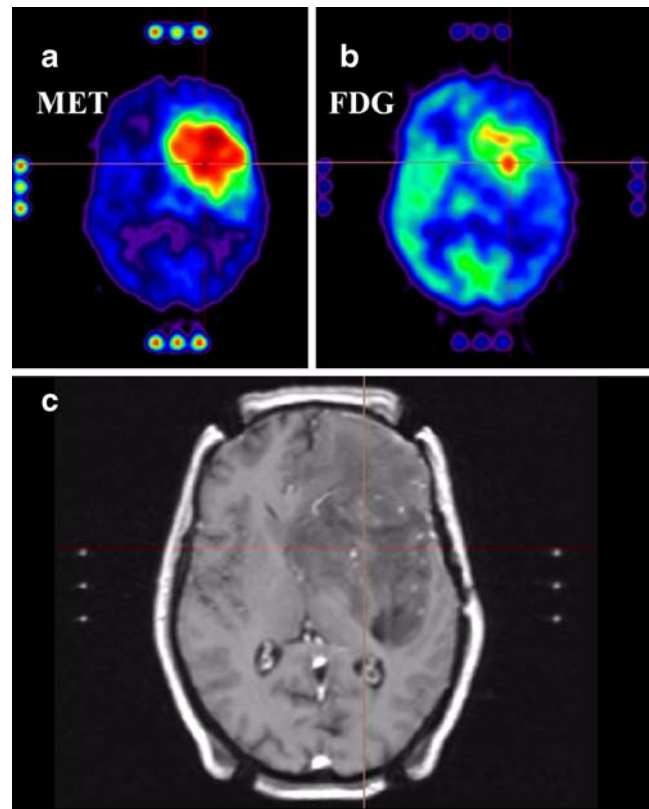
Frontal fibrillar astrocytoma (WHO grade II) explored in MET–PET (a), FDG–PET (b), and MRI (c). MET–PET allows excellent tumor delineation while FDG–PET shows the areas of highest uptake in tumor parts that are not enhanced after MR contrast
